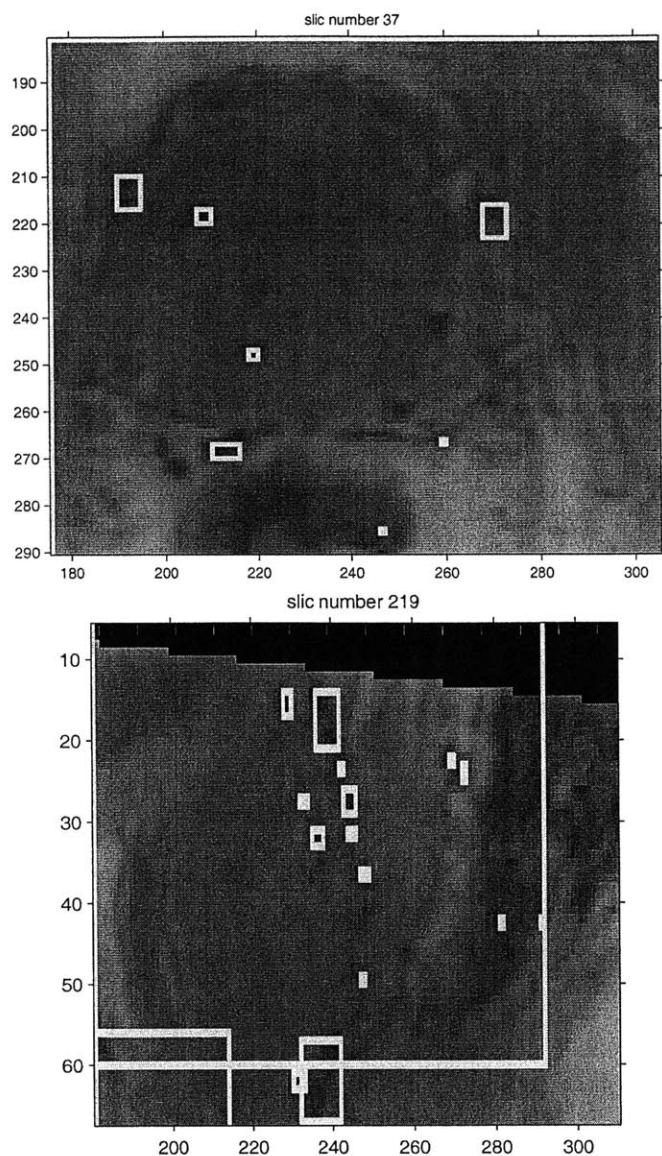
Candidate seeds' bounding boxes generated by the MR seed-finder are overlaid on the MR image. In the axial view (top), the seed-finder successfully finds 6 seeds in the large, central, circular prostate region. The lower-most seed is most likely a false positive corresponding to air in the rectum. The seed-finder glaringly misses a few seeds, which should be completely outlined by their bounding boxes. In the sagittal view, a vertical swath of about ten seeds, and falsely connected seed pairs, is successfully detected. It is not clear whether the candidates detected in the upper right are false positives. The candidates in the dark region are probably false positives, lying in the rectum. The very large bounding boxes are caused by poorly defined region of interest, which includes zero signal areas from 3PR reformatting.
